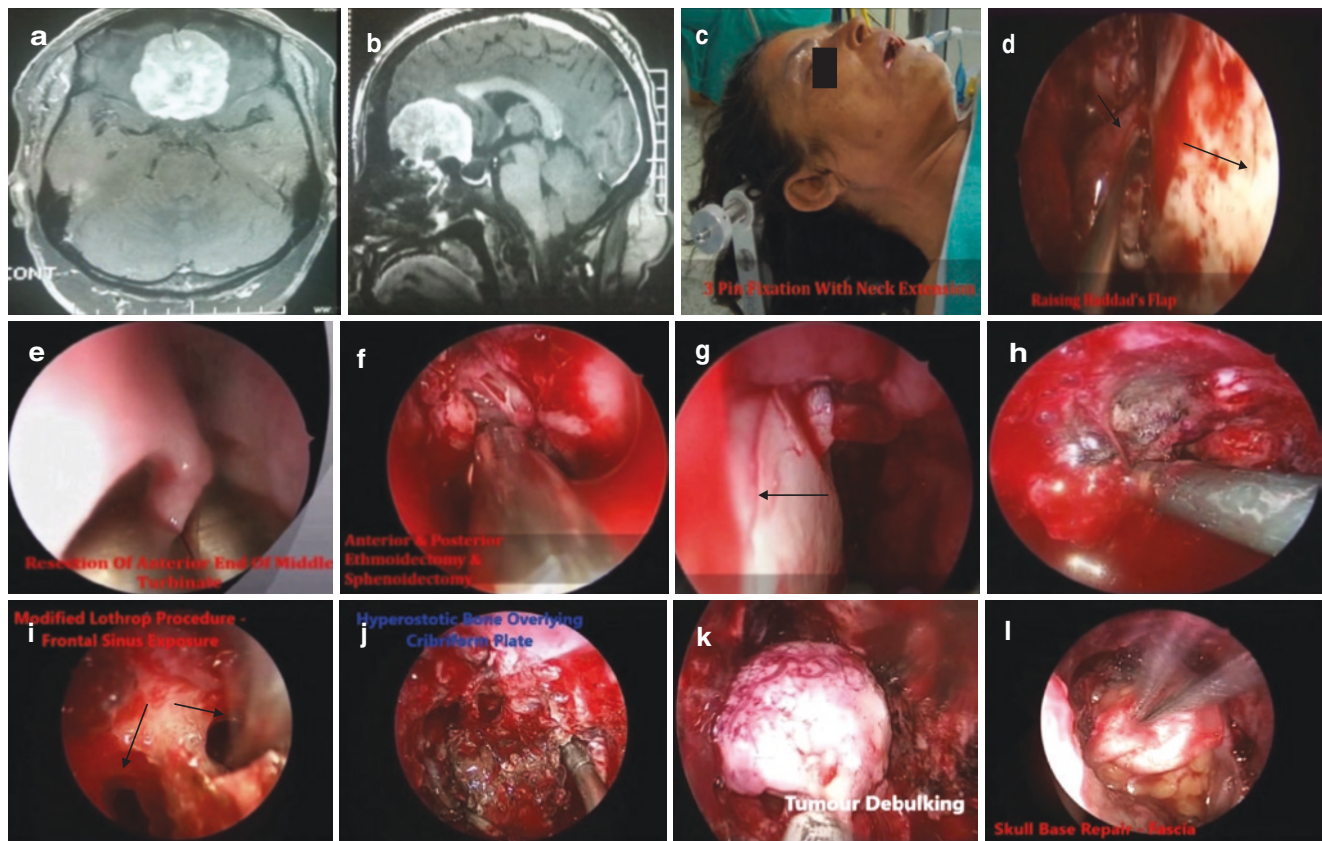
Endoscopic Endonasal Approach in olfactory groove meningioma. (a, b) Contrast enhanced computed tomography depicting tumour arising from the olfactory groove with extradural extension to the anterior cranial fossa. (c) Patient positioned with slight neck extension and the head supported by 3-pin fixation. (d) Hadad flap being elevated on the right side. Septum—long arrow, mucoperiosteum over the septum reflected posteriorly (short arrow). (e) Anterior end of middle turbinate being resected. (f) Complete ethmoidectomy and sphenoidectomy.
